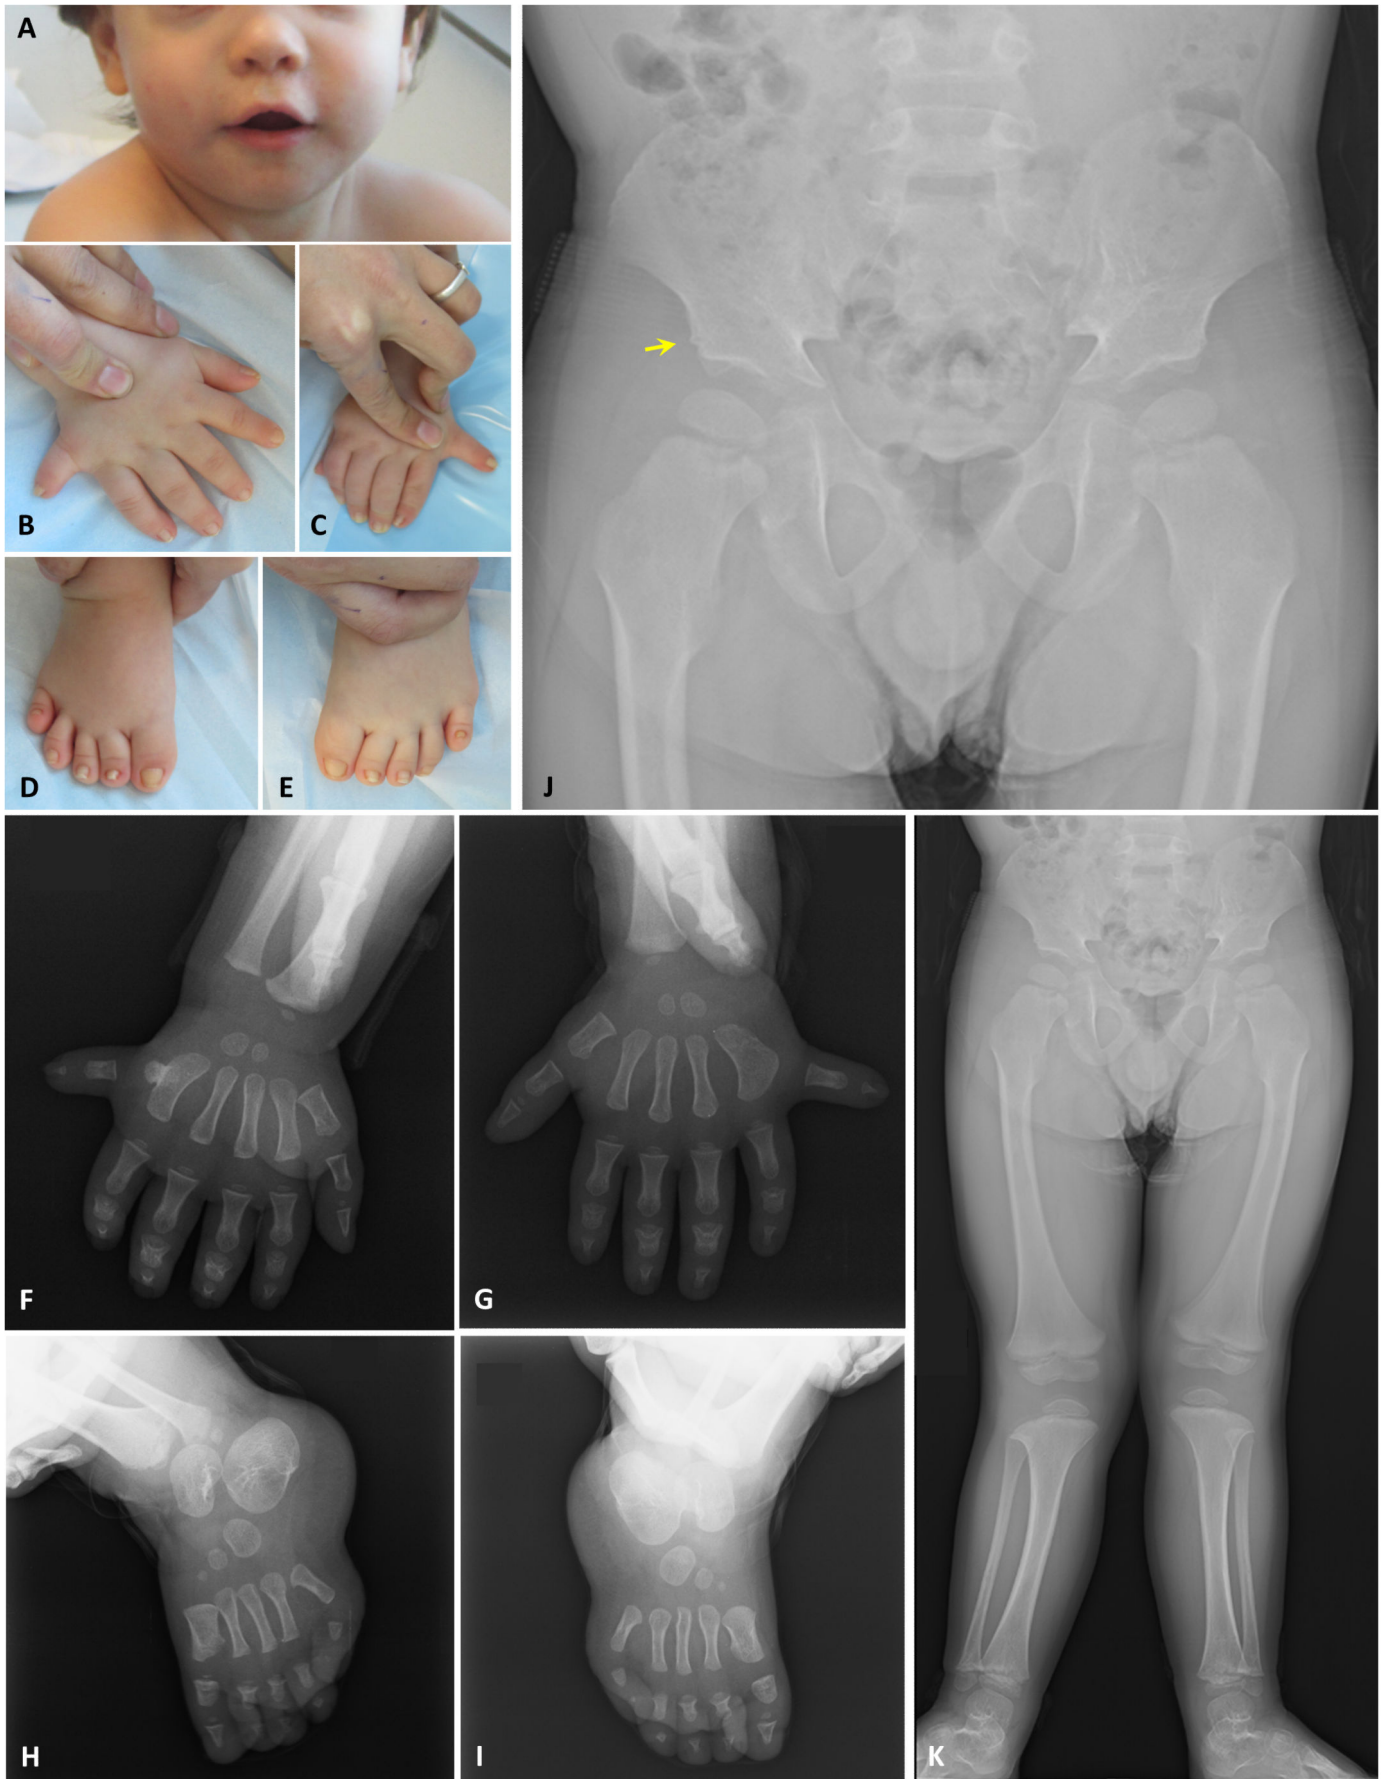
Clinical and radiographic images of a male child with Ellis-van Creveld (EVC) syndrome
